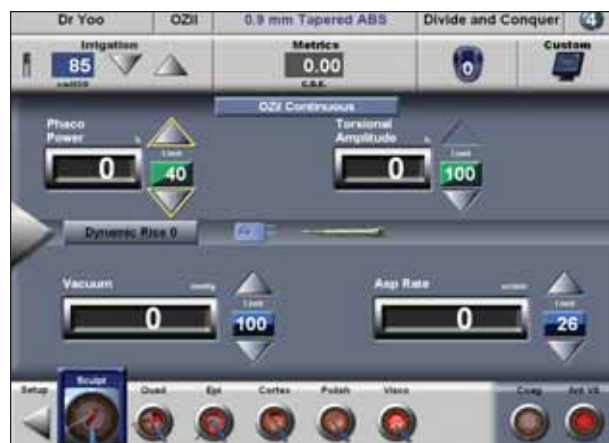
This image shows Dr. Yoo's settings when she combined traditional ultrasound with torsional on a dense lens.
